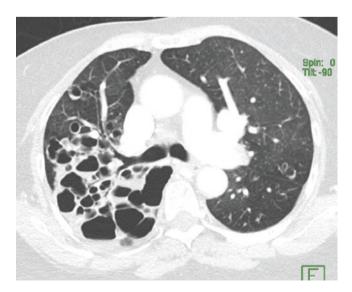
Cystic bronchiectasis. Axial CT image shows multiple cysts in the right upper lung. These cysts are communicating with each other and bronchioles with an air-fluid level in them suggesting infection
